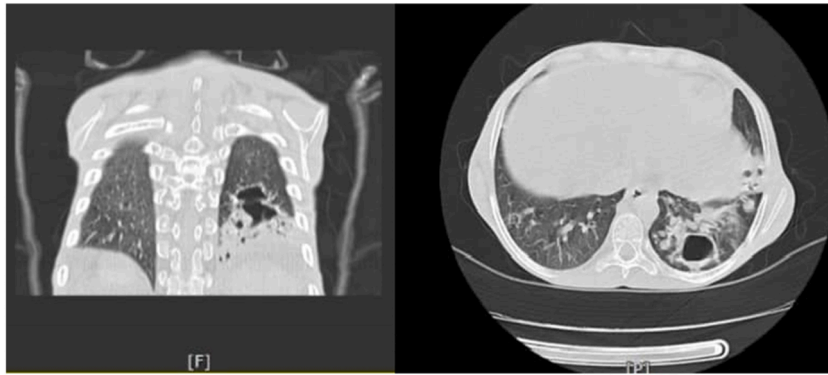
Chest high resolution CT displayed a large area of cystic bronchiectasis with destruction of the lung in the left lower lobe.
